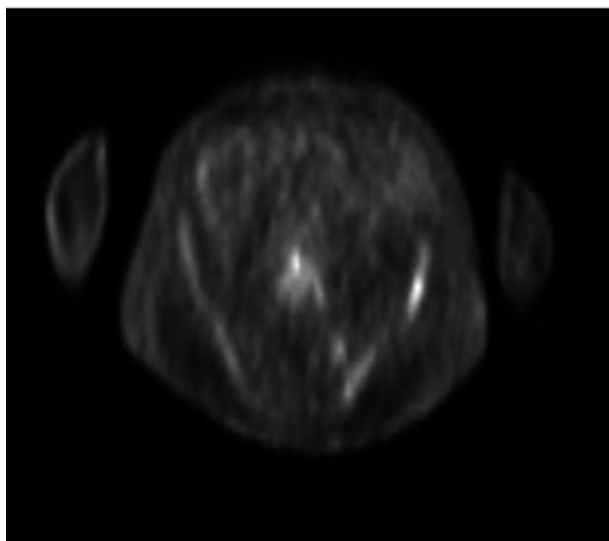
PET/CT demonstrating foci of increased metabolic activity corresponding to lytic lesions in left iliac crest (SUV) = 5.7.
